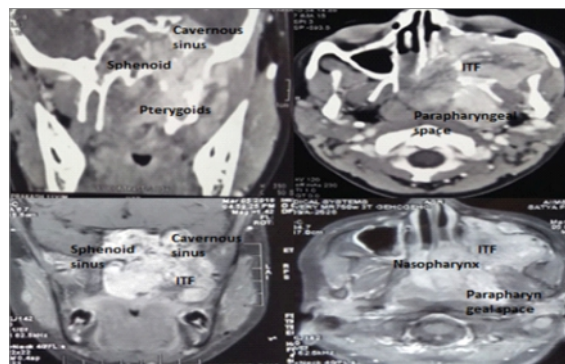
10 CECT and MRI of JNA with intracranial extension
